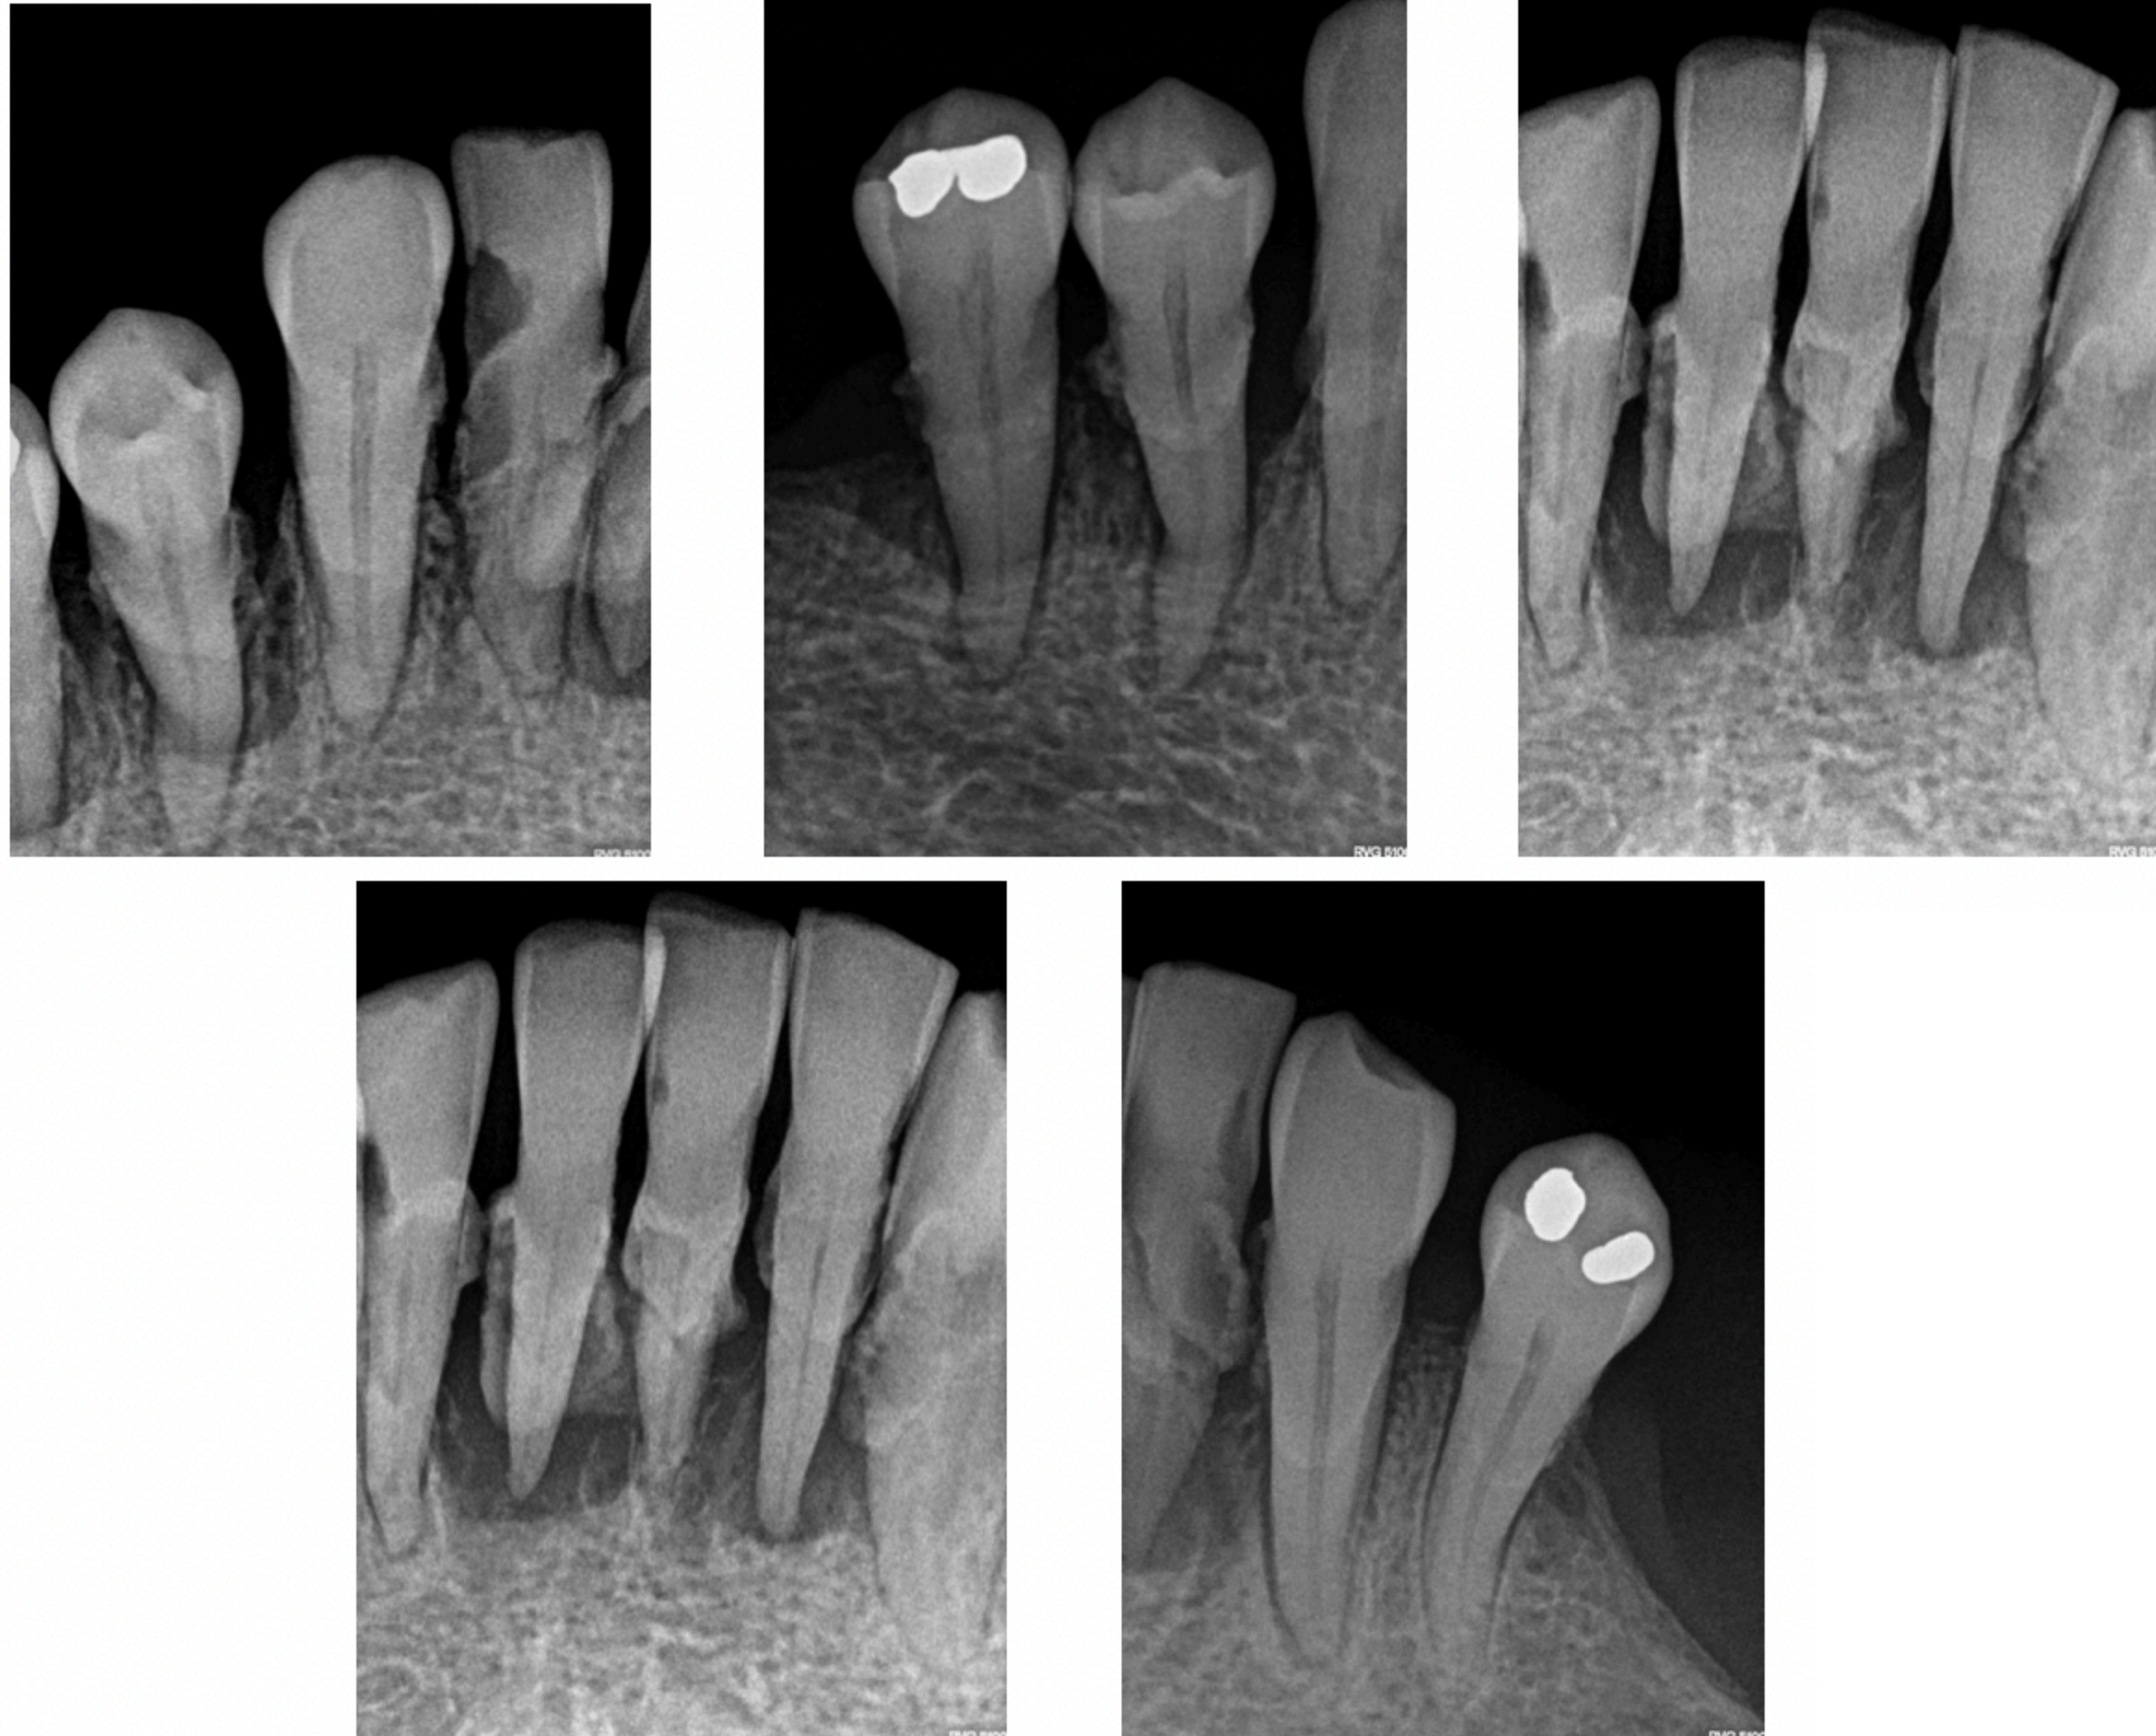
Mandibular periapical radiograph series (right posterior, anterior, left posterior).
